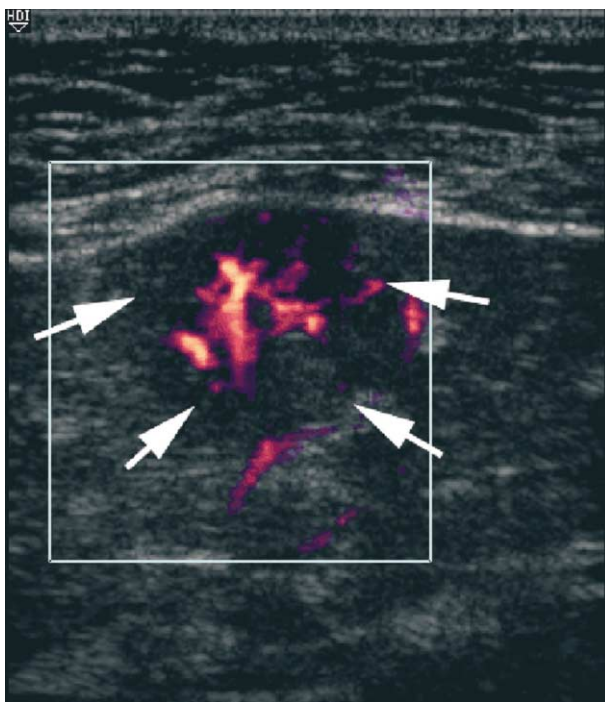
Power Doppler study showing hypervascularity in a superficial hepatocellular carcinoma in a cirrhotic liver.
